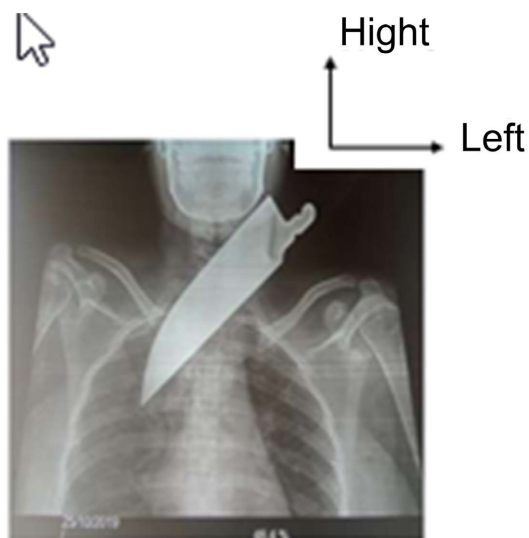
Front view cervico-thoracic X-ray.
